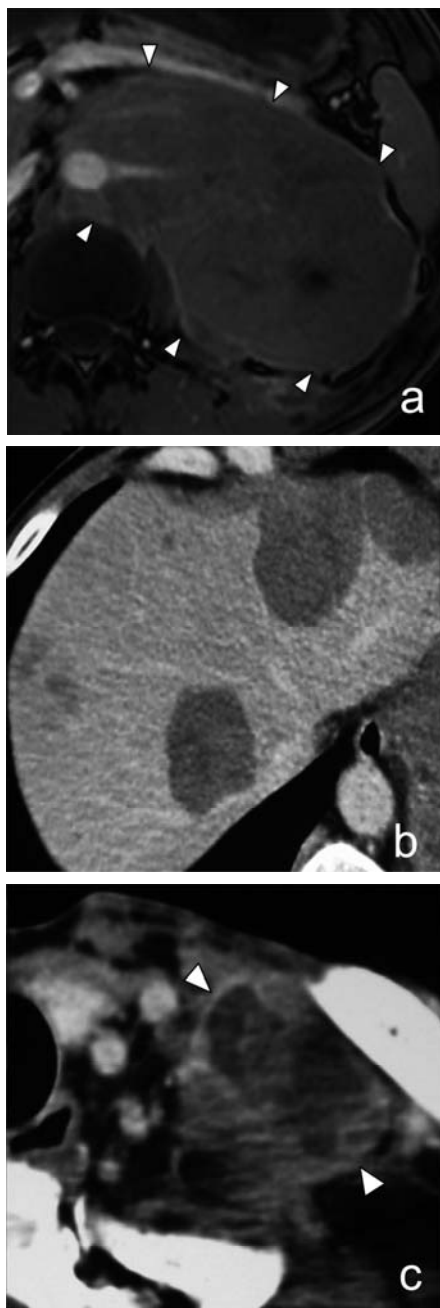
A Gadolinium-enhanced T1-weighted MRI revealed a renal small cell carcinoma measuring $18 \times 11 \times 10$ cm in diameter that displaced the upper pole of his left kidney (a). Abdominal CT and thoracic CT revealed multiple liver metastases (b) and metastasis in Virchow's subclavian lymph node (c), respectively.
